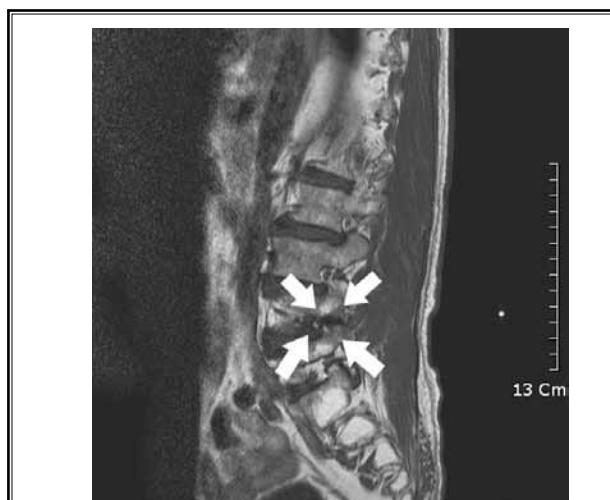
Grade 3 foraminal stenosis: T1-weighted sagittal image of 76-year-old woman with right lower extremity pain shows compressed right L4-L5 nerve root (arrows).
